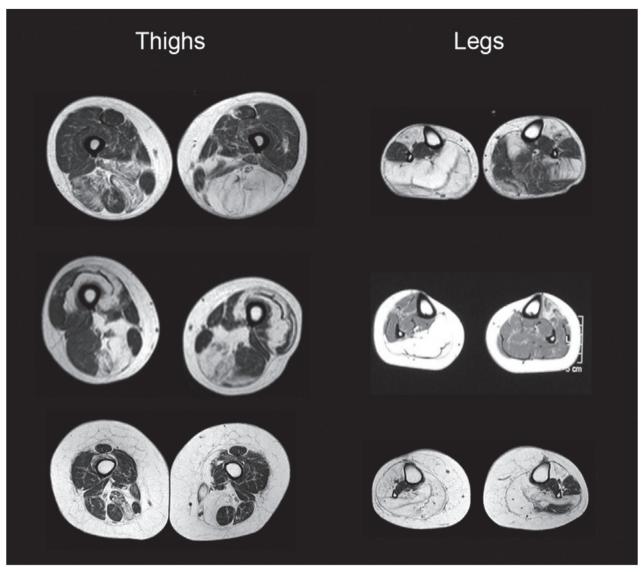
Muscle MRI of patients with Facio-Scapulo-Humeral muscle dystrophy. Muscle MRI of different patients with FSH muscle dystrophy showing asymmetries in the thighs and legs studies.
